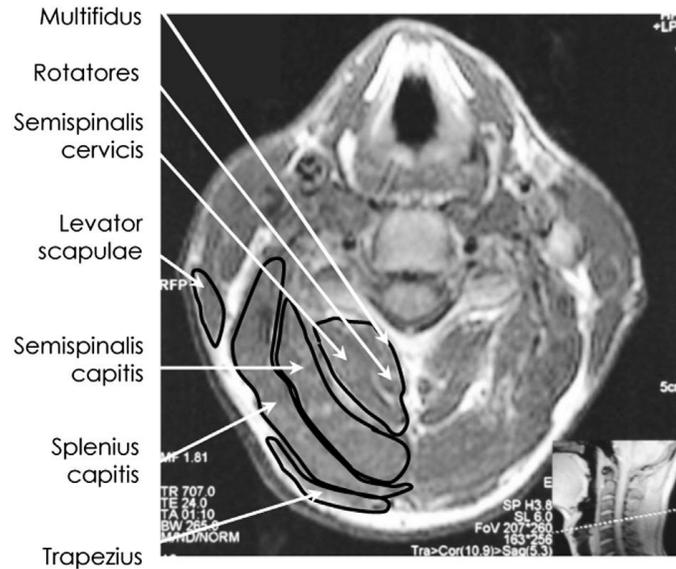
MRI scan of the neck of a healthy 45 year old male showing the cervical extensor muscles from an axial view. Adapted from “Function and structure of the deep cervical extensor muscles in patients with neck pain,” by J. Schomacher & D. Falla, 2013, *Manual Therapy*, 18, p. 361.
